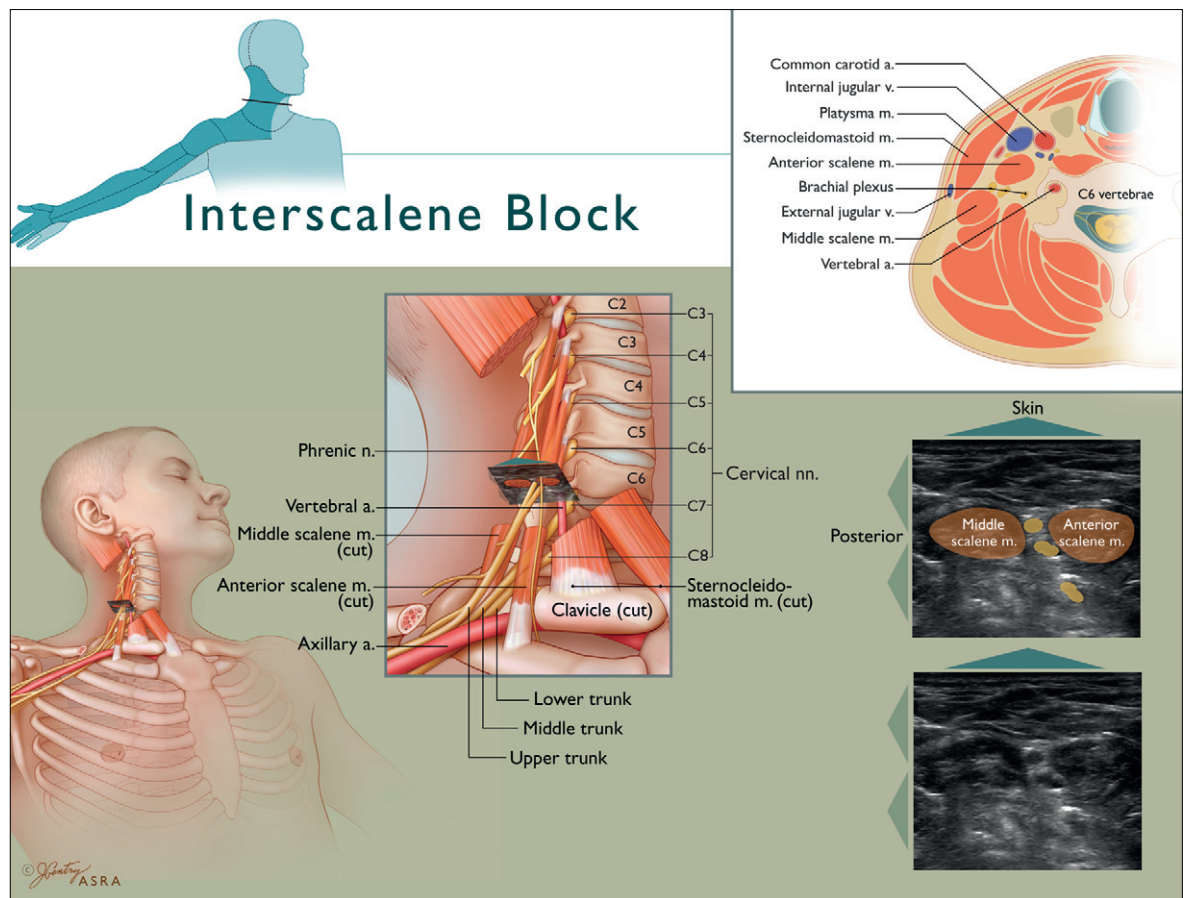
Anatomy for the interscalene block with ultrasound correlation
